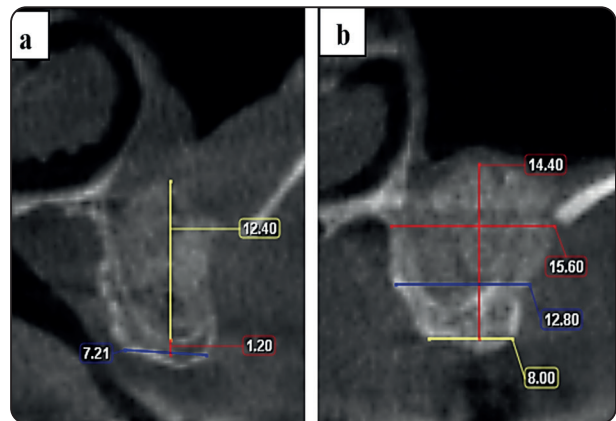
Reformatted coronal CBCT images revealing: a) Bone height, measured after considering trimming of the alveolar crest: Residual ridge height (red vertical line) and graft height (yellow vertical line). b) Bone width: measured at three levels along the bone height: at the crest, at the middle third, and at the apical third.
